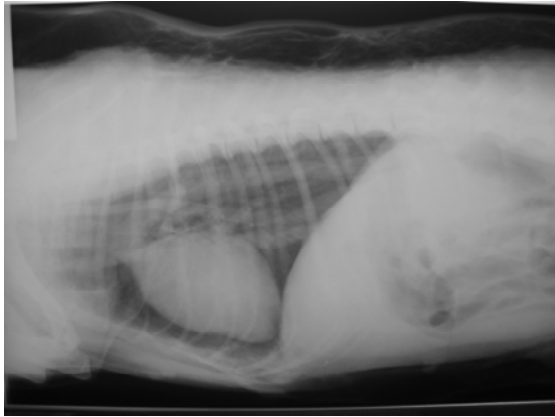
Laterolateral radiography; presence of free air under skin (subcutaneous) in thoracic and abdominal regions, elevation of the heart and recognizable of pulmonary and mediastinal vessels
